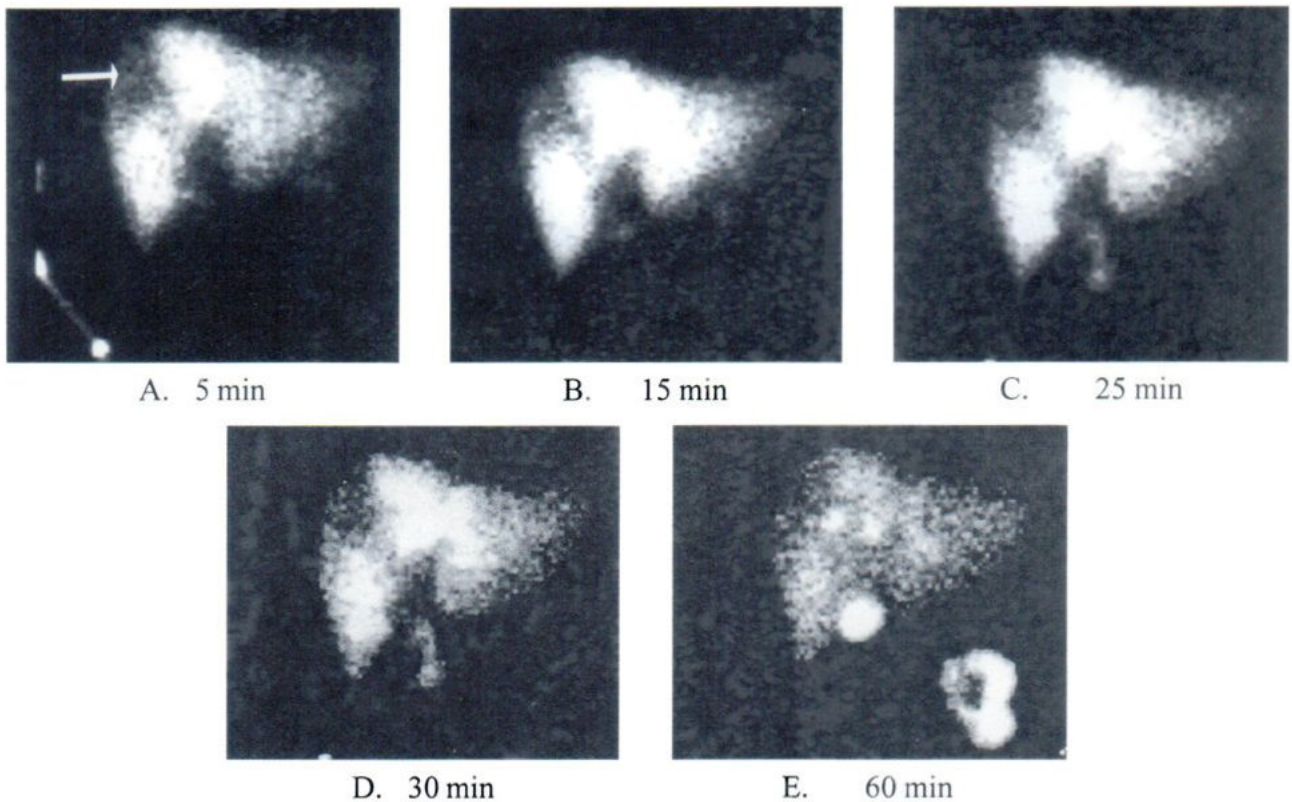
Cholescintigraphy done on the seventh day after octreotide injection: There is resolution of bile leakage. Large photon-deficiency area (arrow) is noted in the area of the known liver laceration of the right lobe of the liver, possibly due to parenchymal loss secondary to infarction or fibrosis. The value of serum liver enzymes decreased at this time.
